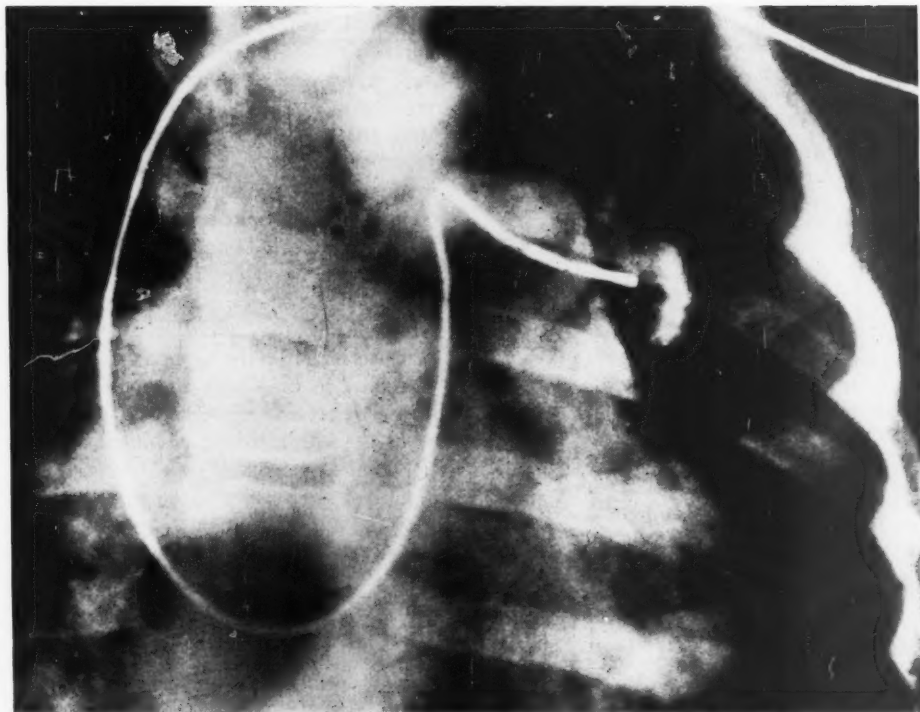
JLB, 4-year-old girl. Spot film of single-lumen sound catheter with tip in the left pulmonary artery. The transducer at the tip is radiographically more dense than the rest of the catheter.
